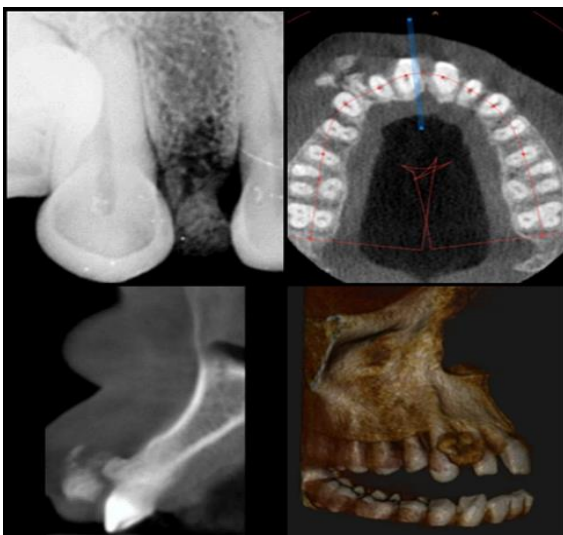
Pre-operative radiographic analysis – IOPA and CBCT)
